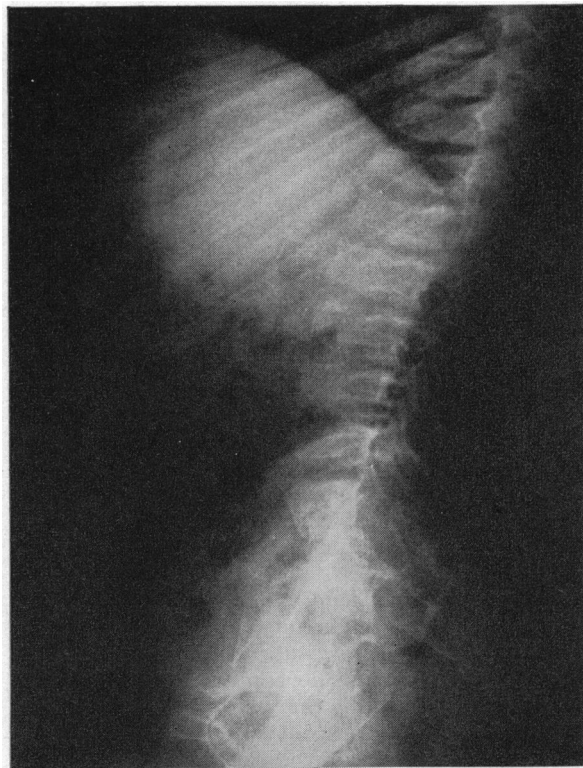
(Patient A).—The lateral roentgenographic view of the dorsal and lumbar spine shows a very pronounced flattening and elongation of the vertebral bodies. The superior and inferior margins of these bodies are irregular and there is a slight narrowing of the joint space. The entire spine shows a moderate degree of kyphosis.
